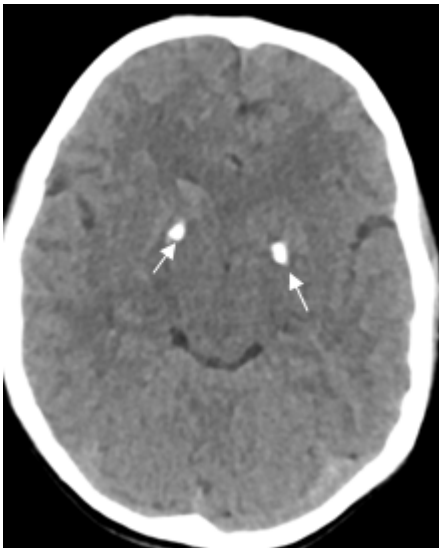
Axial nonenhanced CT image of head shows bilateral symmetrical small GPCs (arrows)
